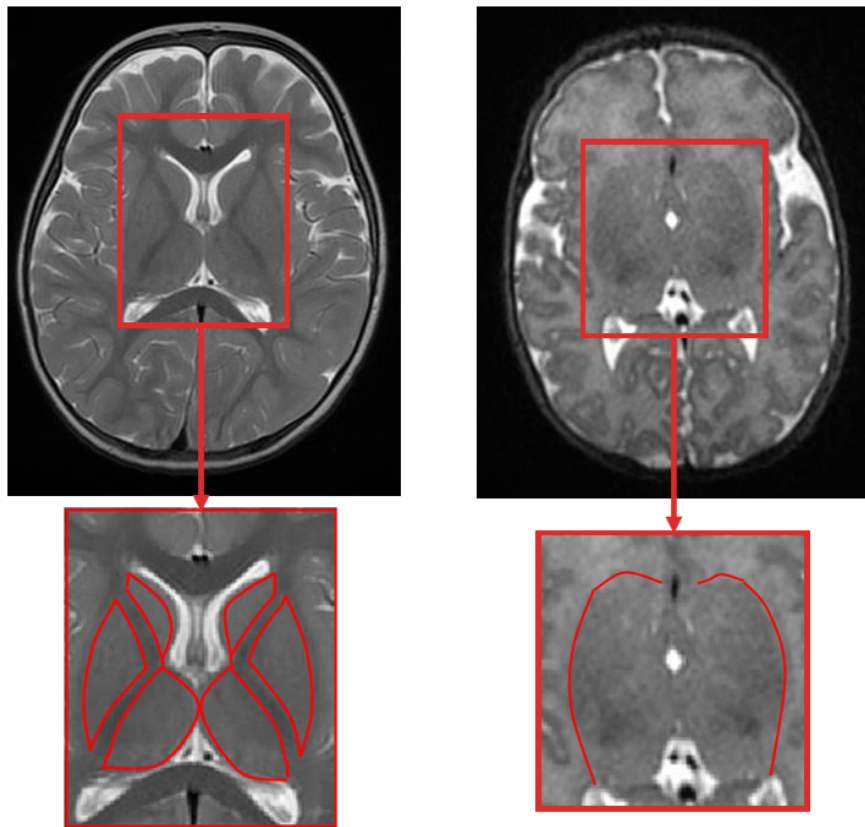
Differences in the deep grey matter between an adult (left) and infant (right) brain MR image. The contours of this region are marked in red.
